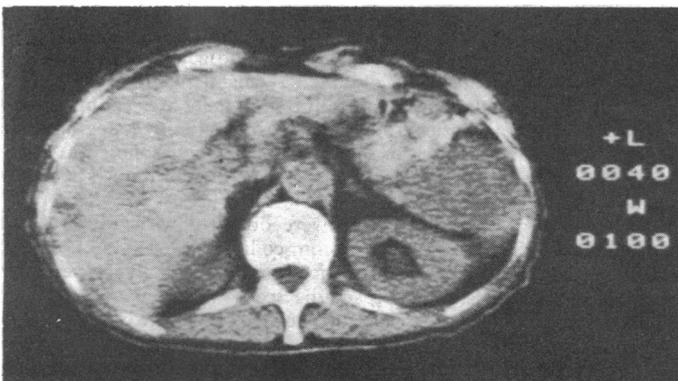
Computed tomography showing multiple hepatic metastases 10 months after surgery.
